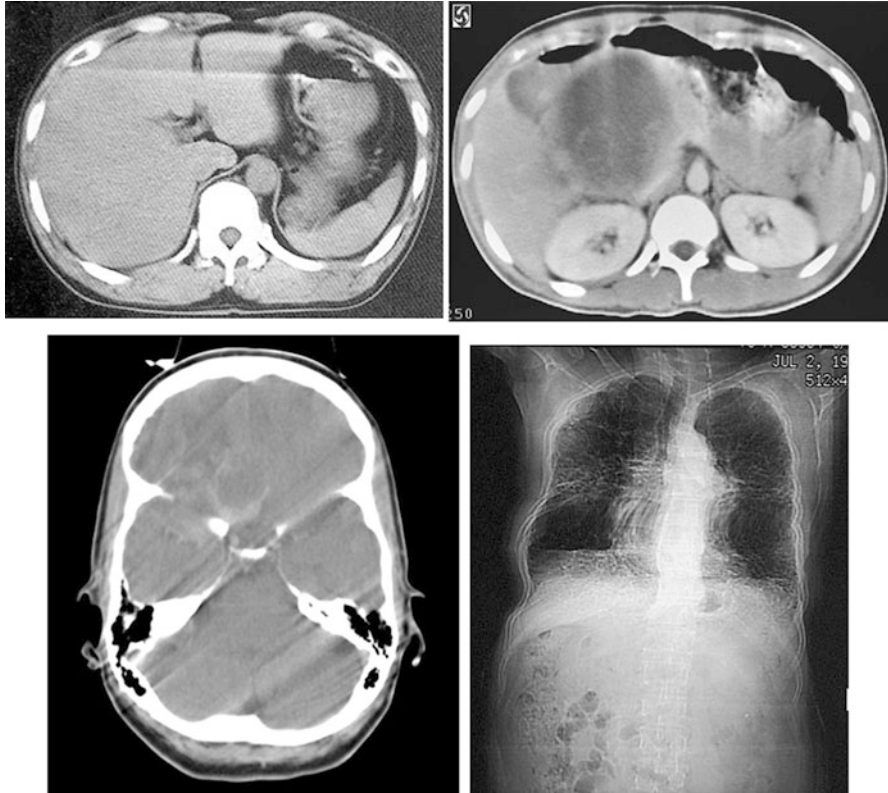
Motion artifacts in the CT images of various body parts
